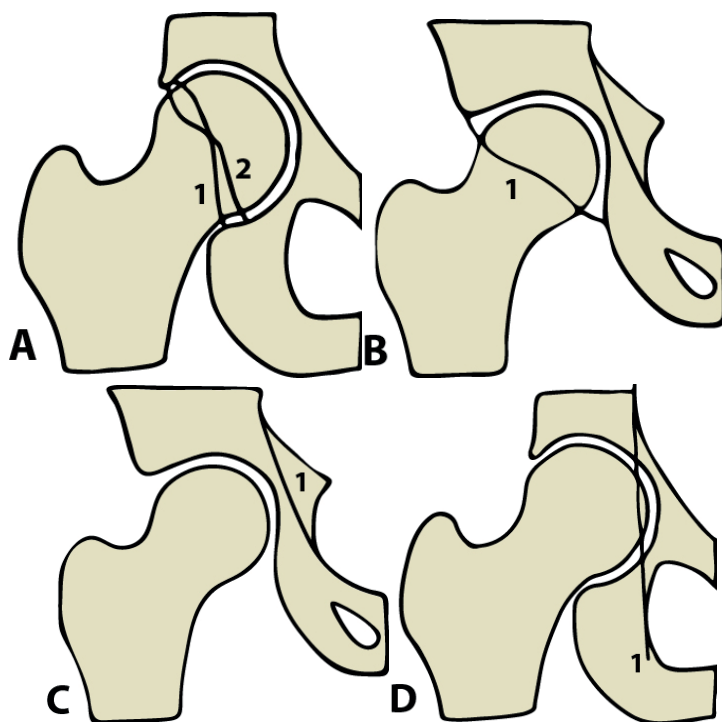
Radiographic measurements of pincer morphology. A: The crossover sign is present when the posterior acetabular wall (line 1) intersects with the anterior acetabular wall (line 2). B: The posterior wall sign is positive when the posterior acetabular wall runs lateral to the femoral head center. C: The ischial spine sign is positive when the ischial spine (part 1) projects medially to the pelvic rim. D: Coxa profunda is present if the acetabular fossa extends medially to the ilioischial line (line 1). Protrusio acetabuli is present when the femoral head extends medially to the ilioischial line (line 1).
